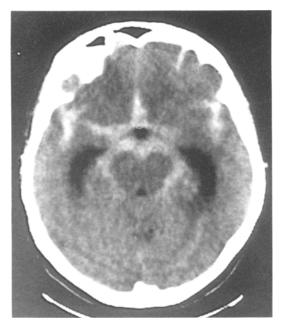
CT scan showing large quantity of blood in the basal cisterns
